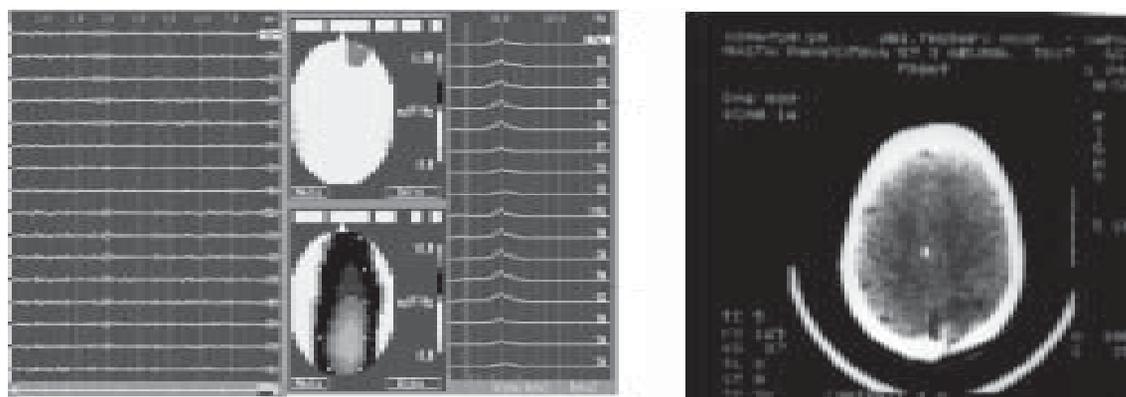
EEG and CT-scan (postoperative cyst in right occipital region) 2 months after operation.
